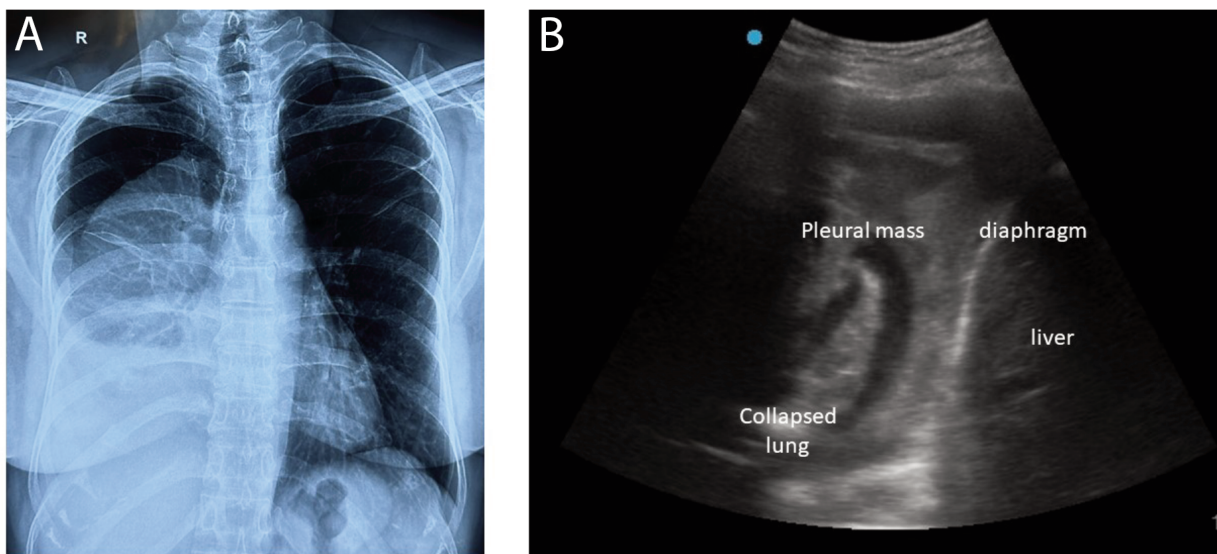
A) Chest X-ray on presentation s/o a large lobulated mass-like lesion in the right hemithorax with blunting of the right costophrenic angle. B) Chest ultrasonography showing a mass lesion in the pleura.
